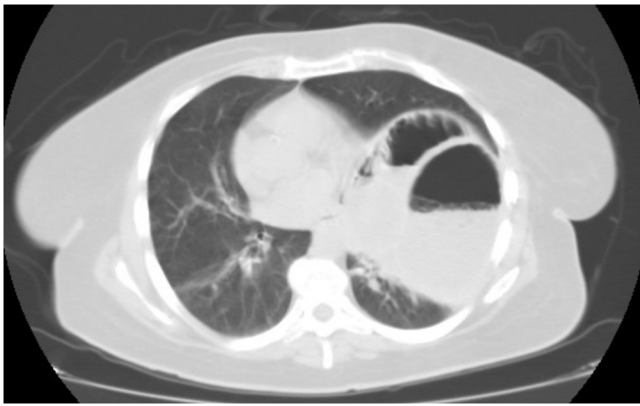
Thorax-abdominal CT-scan showed a diaphragmatic herniation of the left side with malposition of dilated transverse and descending colon in the chest. In addition to this consensual complete atelectasis of the medial-basal part of the lung, and a right deviation of the mediastinal structures.
